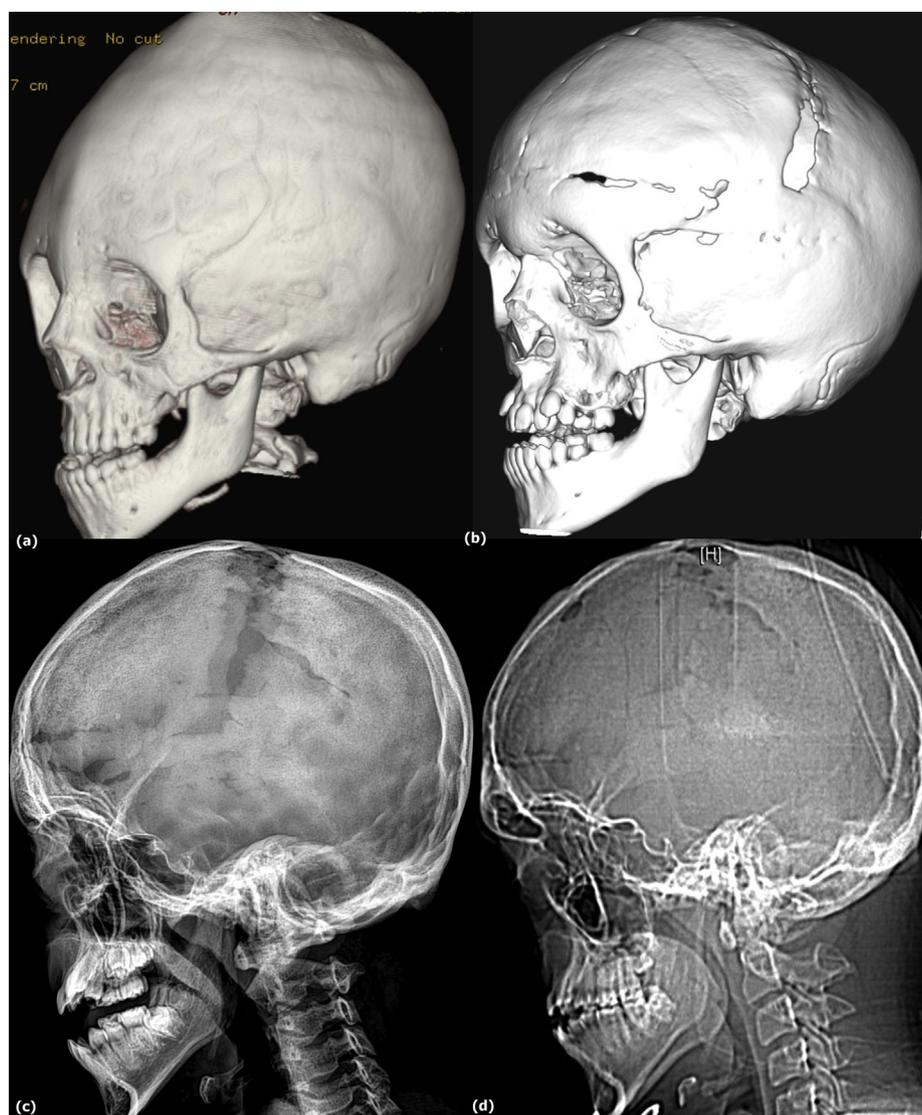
Case presentation. (a) Preoperative CT scan demonstrating a diffuse beaten copper appearance. (b) Five-year postoperative follow-up CT showing favorable progress and (c) recurrent beaten copper appearance 6 years postoperatively. (d) Disappearance of the beaten copper appearance 6 years after an endoscopic third ventriculostomy.
